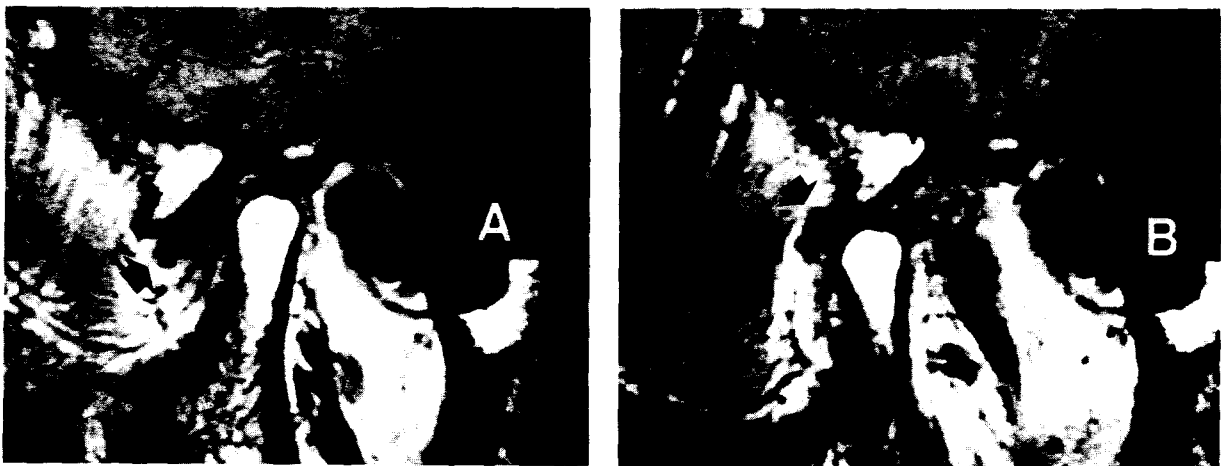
A amorphous disc (arrow) in closed mouth position (A) and a amorphous disc (arrow) in open mouth position (B) are seen on T1-weighted sagittal magnetic resonance images of the temporomandibular joint with anterior displacement but without reduction of the articular disc.
